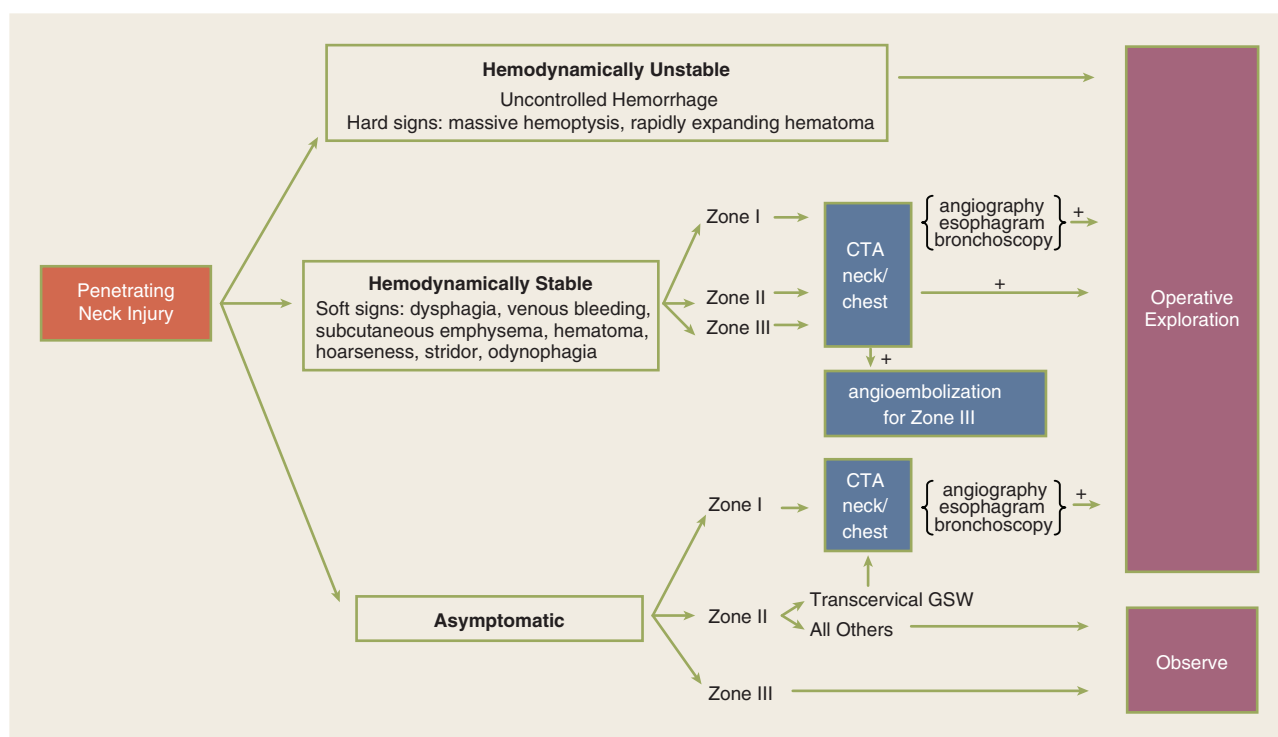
Algorithm for the management of penetrating neck injuries. CT = computed tomography; CTA = computed tomographic angiography; GSW = gunshot wound.
